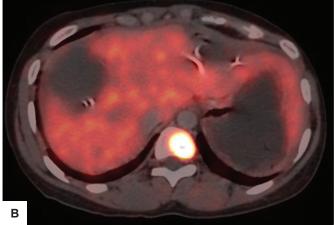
Follow up ⁶⁸Ga DOTATATE PET/CT scan after surgery. (A) Scan shows avid uptake in Periportal lymph node; (B) Avid uptake in D10 vertebra.
